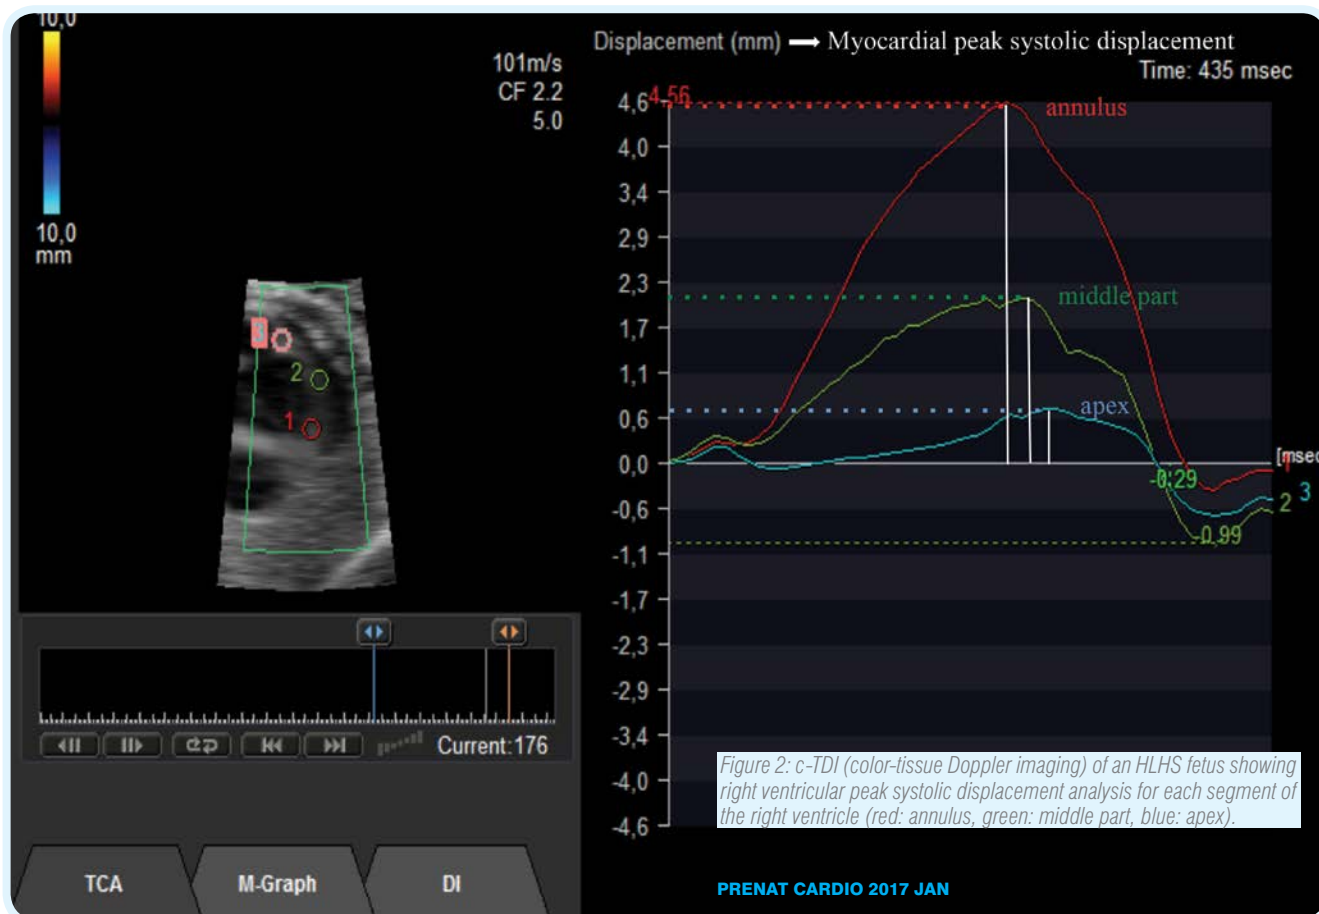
c-TDI (color-tissue Doppler imaging) of an HLHS fetus showing right ventricular peak systolic displacement analysis for each segment of the right ventricle (red: annulus, green: middle part, blue: apex).
